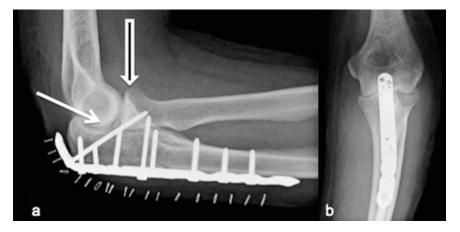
Plain radiographs after ORIF of the simple transolecranon fracture-dislocation in Fig. 8.2 with a precontoured proximal ulna plate. (a) The lateral view demonstrates anatomic reduction of the olecranon fracture
